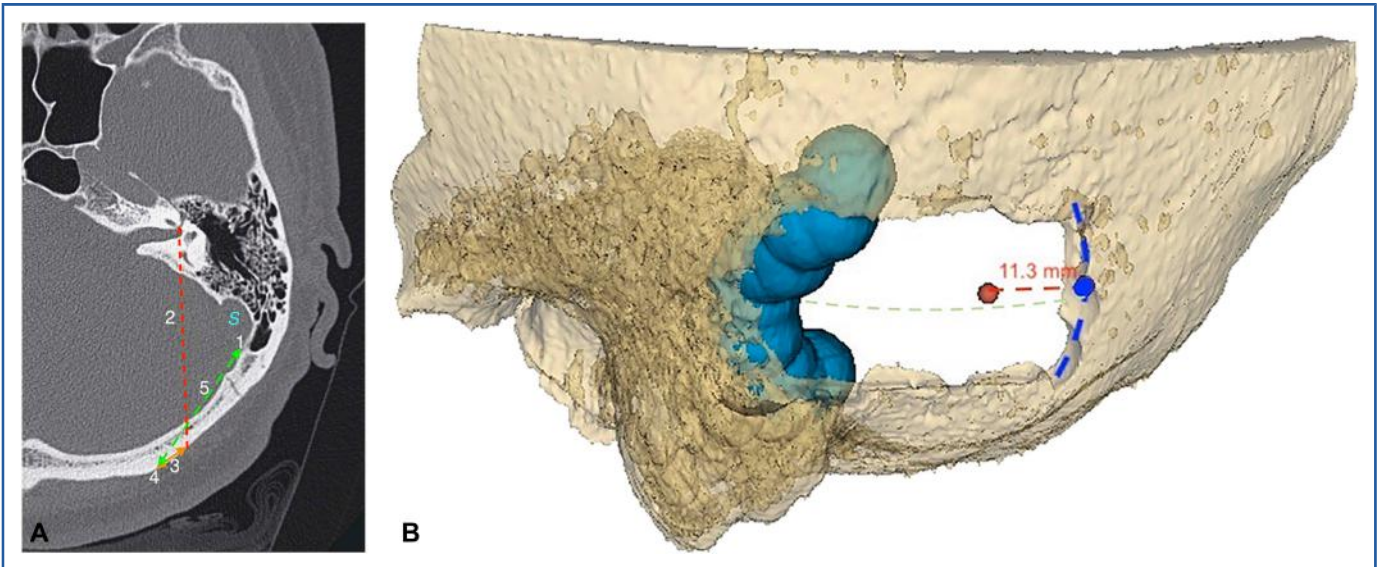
The steps to set the posteromedial edge of the craniotomy in axial computed tomography: A. (1) sigmoid sinus (S) reference identification, (2) fundus–labyrinth line as it hits the occipital squama, (3) addition of 11.3 mm, (4) site of posteromedial edge of the craniotomy, and (5) distance in mm from the sinus to craniotomy. B. 3D rendering of the craniotomy.
